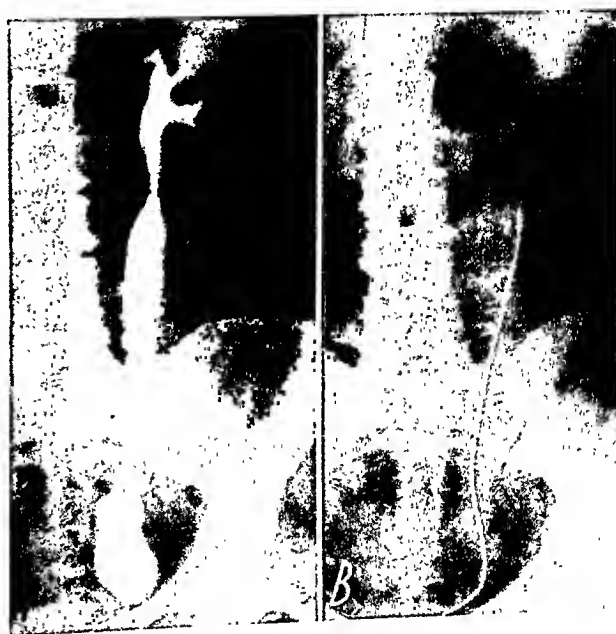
Female, aged sixty, had frequency, pain, cystitis, and distress since 1910, when she was in bed for a month. Roentgenogram of the kidney region suggested a calcification in lower left ureteral area. Pyelogram showed large dilated left ureter (A). Kidney pelvis and calices appeared to be essentially normal. A large dense calcific deposit in the lower left ureter was believed to produce intermittent obstruction in the ureter and the patient's pain (B). Stone was not in contact with the catheter placed in the ureter so that it could be missed without a pyelogram. Previously, such a stone could not be palpated or felt by a catheter, particularly a wax-tipped catheter, or even by a sound. Now with opaque medium in the ureter, so-called ball-valve stones may be apprehended whether or not in contact with a catheter or other instrument introduced into the ureter. A left ureteronephrectomy eliminated the patient's symptoms.
